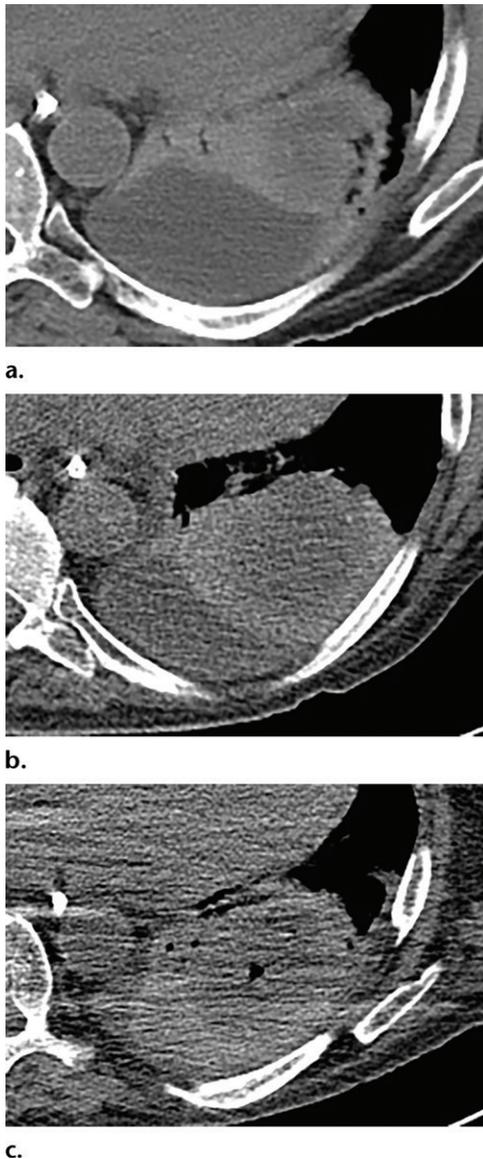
Necrosis in a 59-year-old man who underwent renal transplant. (a) Axial CT image demonstrates a necrotic consolidation in the left lower lobe with adjacent pleural effusion. (b) Axial CT image depicts enlargement of the consolidation after 20 days with new pleural thickening. (c) Axial CT image shows central cavitation in the left lower lobe lesion. (d) Gross photograph shows the left lung with the necrotic cavity exposed.
